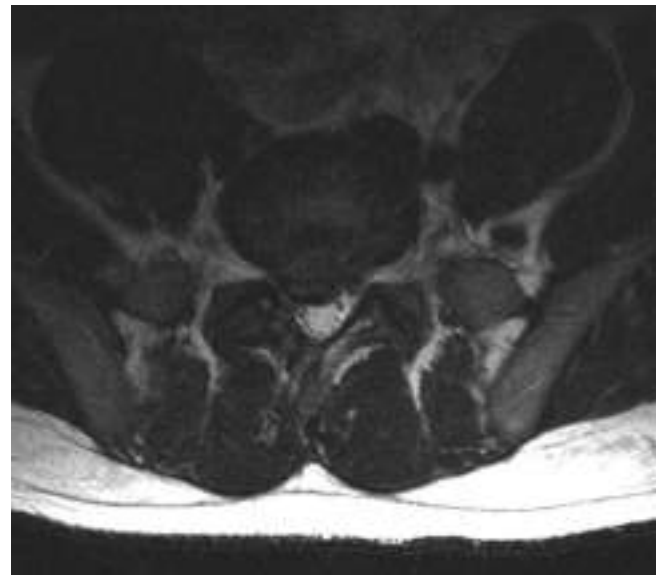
Right L5/S1 disc herniation preoperative MRI
